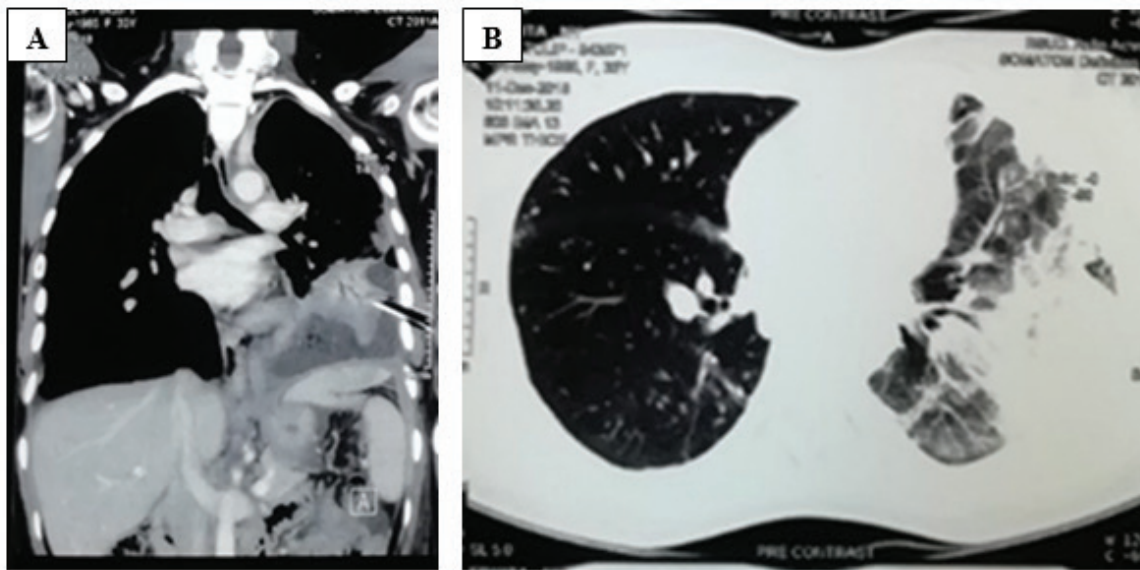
Chest CT showed pleural effusion and multiple subcentimeter nodules as well as a ‘tree in bud’ appearance throughout the lung parenchyma (A & B).
